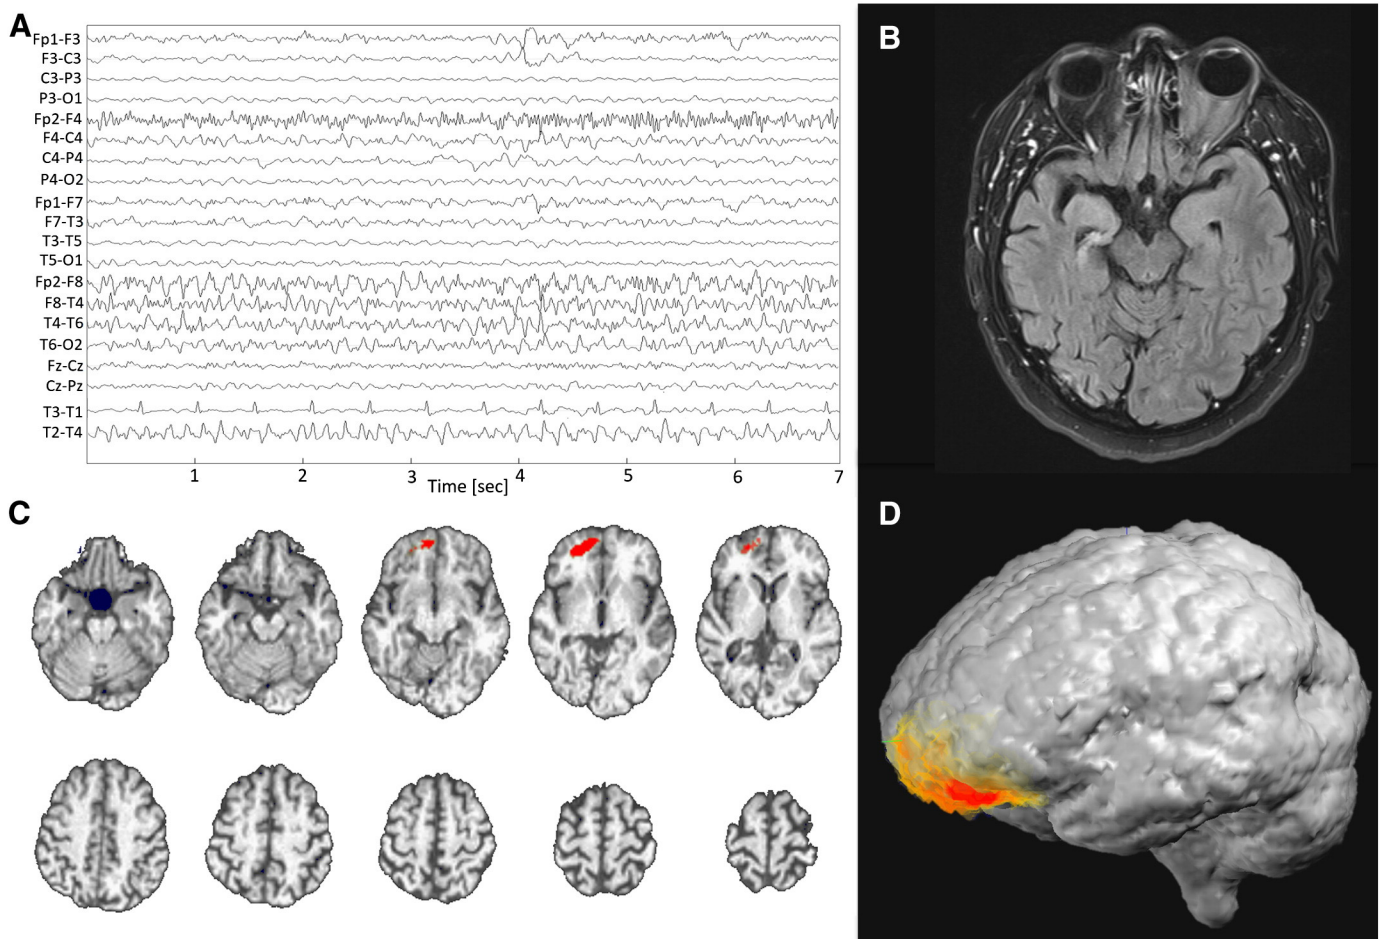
(A). Ictal EEG activity during the seizure that preceded religious conversion was localized to the right temporal lobe. (B) MRI (T2, axial slice) of the patient’s brain shows prominent right mesial temporal sclerosis. (C). Comparison of resting-state EEG periods recorded during postictal psychosis of delusional religious conversion and those recorded during interictal epochs using topographical electrophysiological analysis in the frequency domain revealed a significant hyperactivation in low-gamma power (30–40 Hz) in left PFC during the psychotic event. EEG generators are projected on the patient’s MRI in axial slices. (D) The same EEG generators projected on the patient’s MRI in 3D reconstruction.
